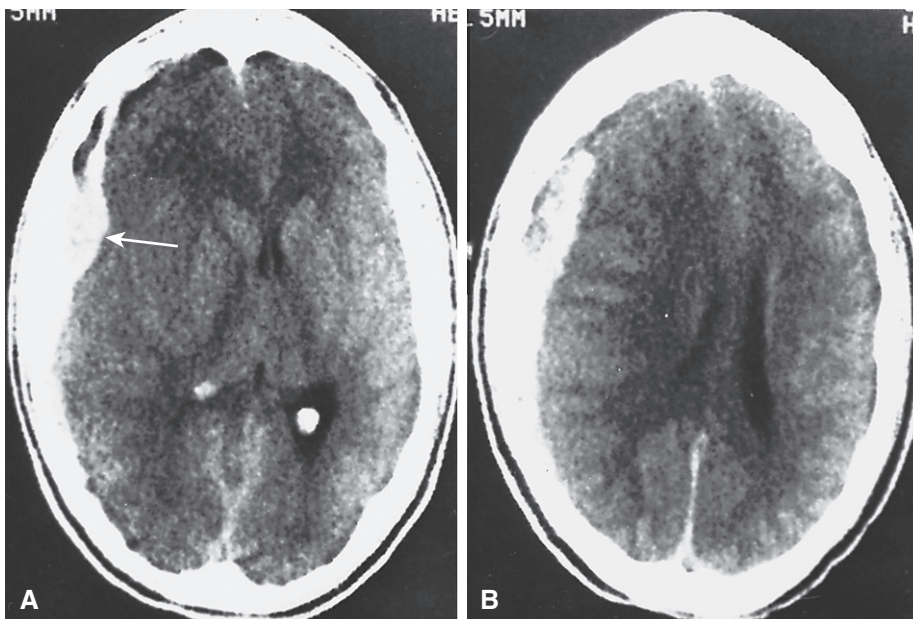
Computed tomography of subdural hematoma. A, Acute subdural hematoma can be seen (arrow). B, Note the marked midline shift, with displacement of lateral ventricles toward the left. (From Haaga JR, Alfidi RJ [eds]: *Computed Tomography of the Whole Body, Vol 1*. St. Louis, Mosby, 1983, p 187.)
